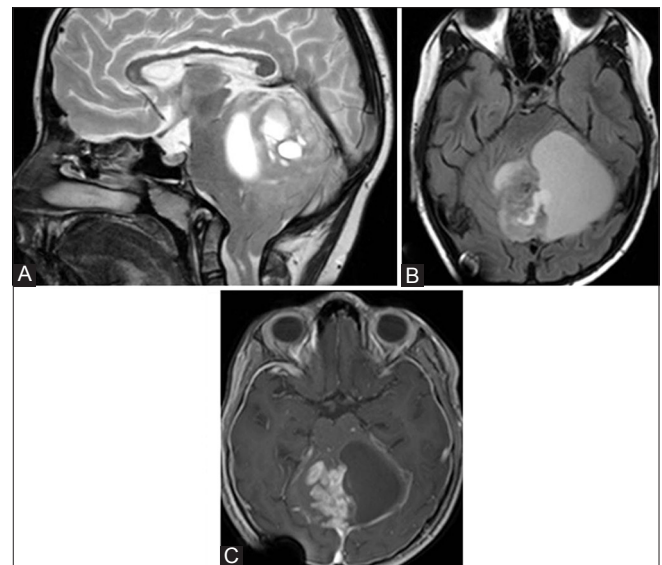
(A-C): An 11-year-old female with cerebellar ganglioglioma. (A) Sagittal T2W image showing fairly well-defined mixed solid cystic lesion (B) Axial T2 FLAIR image showing no inversion of cystic contents (C) Axial T1W post-contrast image showing homogeneous enhancement of the solid component and cystic wall enhancement
